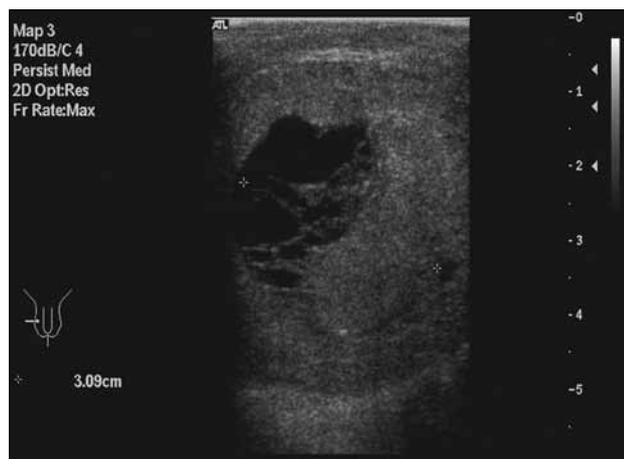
Ultrasonography of the right testis showing an isoechoic lesion with a cystic component.
